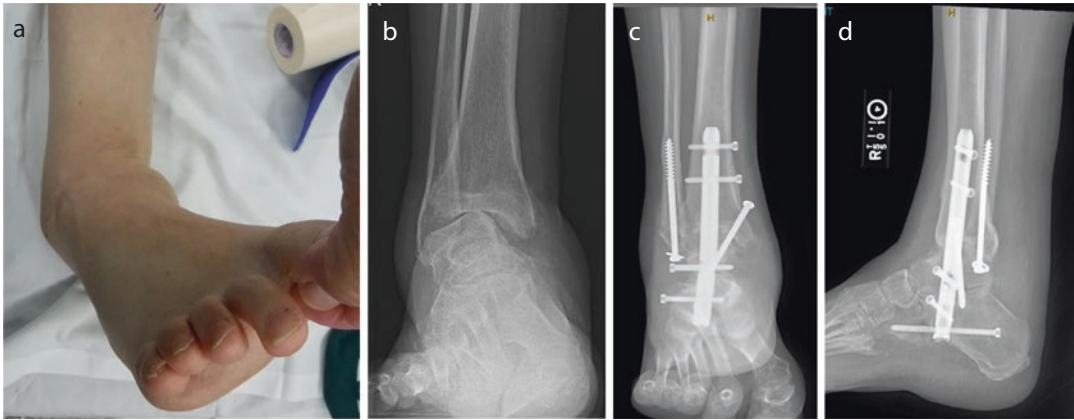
This 63-year old neuropathic diabetic male developed this deformity after multiple ankle “sprains” (a, b). Radiographs at 1.5 years following ankle fusion with retrograde locked intramedullary nail and augmented fixation (c)
